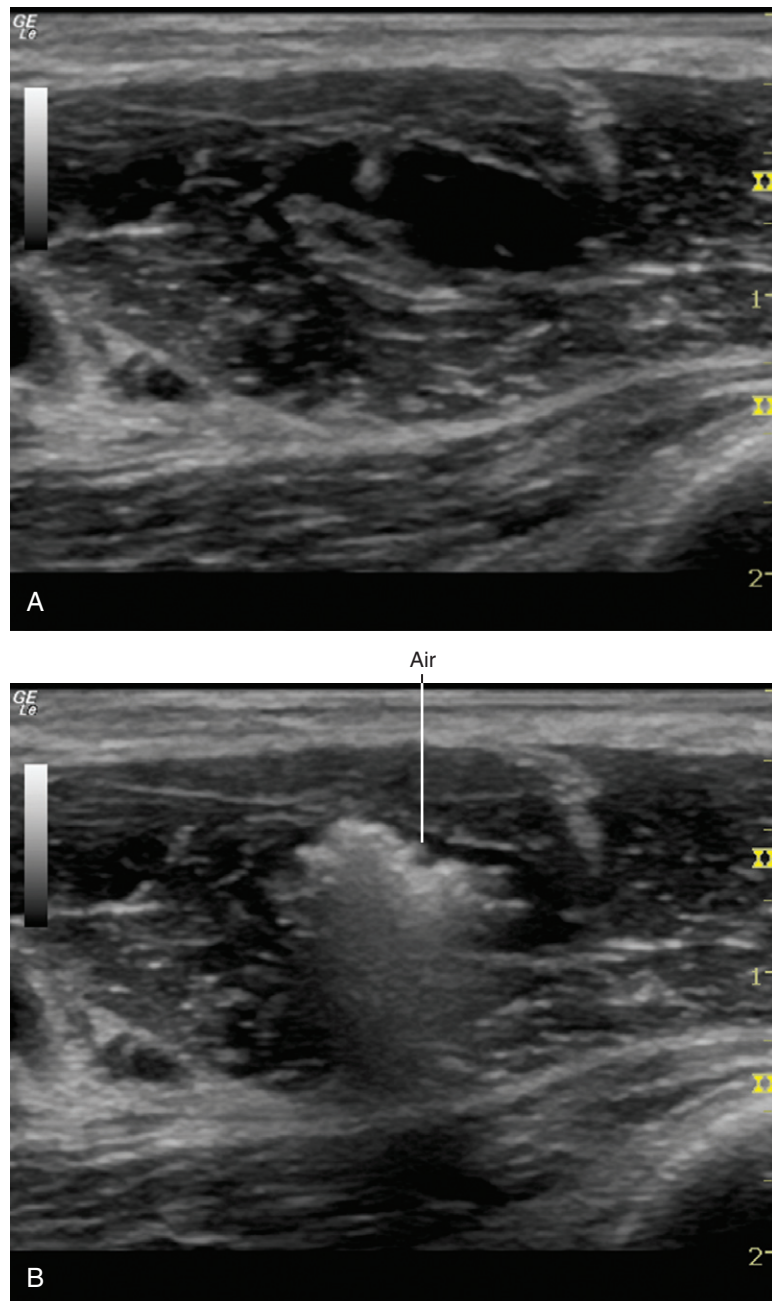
A strong echo and acoustic shadowing are observed when air is inadvertently injected during musculocutaneous nerve block in the axilla. Sonograms before injection (A) and after injection (B) are shown.
